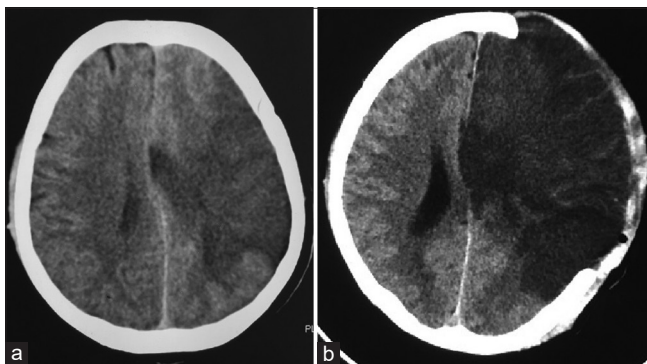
Computed tomography brain plain. (a) Large hypodensity in the left middle cerebral artery territory with mass effect on the lateral ventricle and midline shift to the right. (b) Postoperative image after decompressive craniectomy showing adequate decompression of the left cerebral hemisphere
